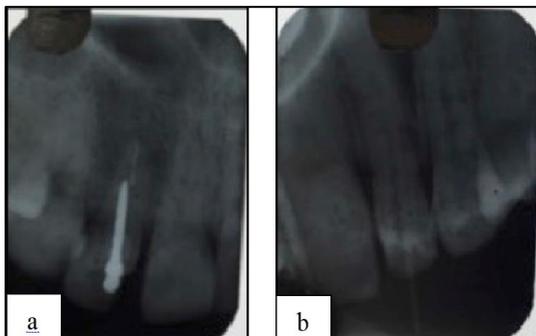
(a): Zirconia Post Radiograph; (b): Fiber Post Placement (Radiograph)
